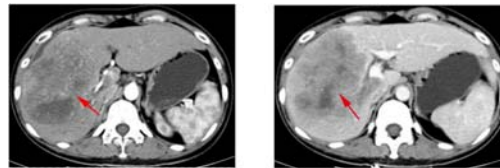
Preoperative contrast-enhanced CT image. The arrow indicated the tumor lesion.
